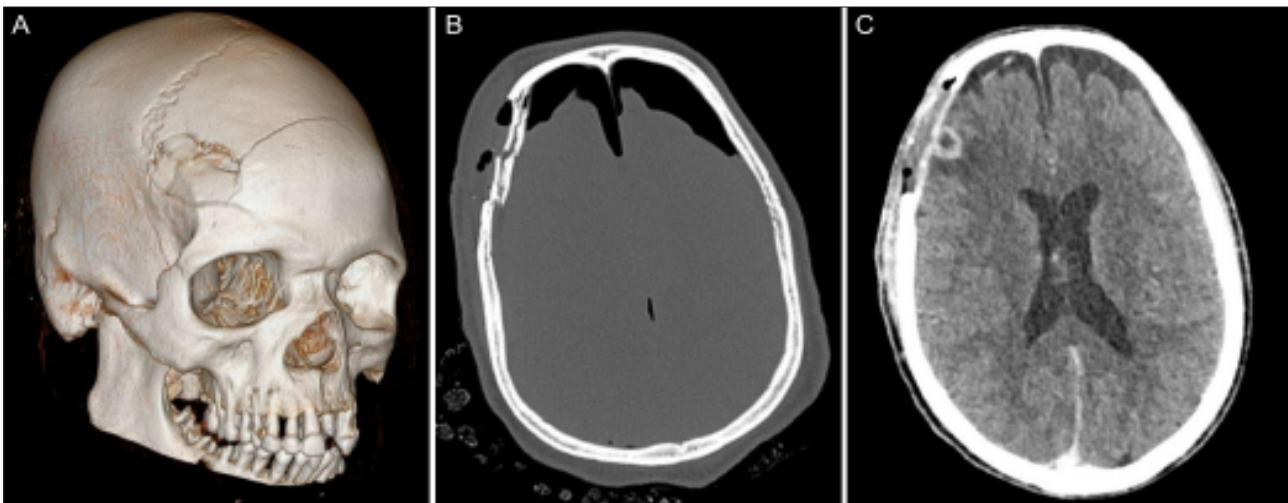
A: Three-dimensional reconstruction of computed tomography brain (CTB) images demonstrating a depressed frontal skull fracture. B: Pre-operative CTB (bone window) axial image showing the Mount Fuji sign associated with tension pneumocephalus. C: Postoperative CTB (soft-tissue window) axial image demonstrating craniectomy and new rim enhancing lesion indicating abscess formation.
